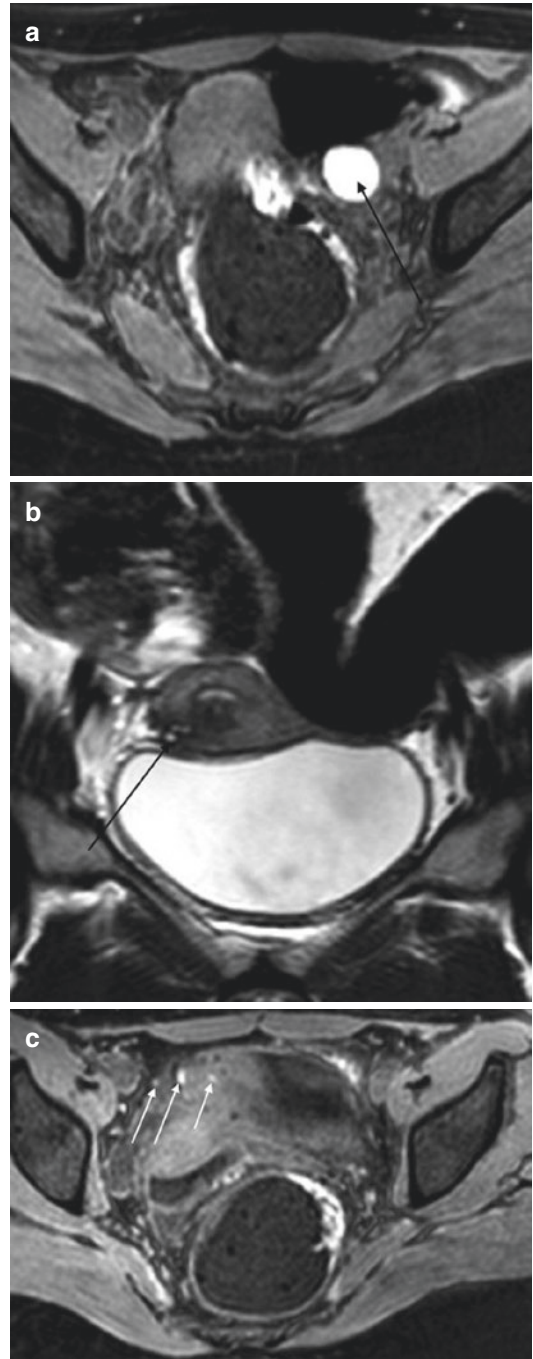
Left endometrioma and bladder endometriosis in a 16 year-old girl. History of cyclical pain after resection of an one-eyed uterine horn. (a) MR imaging: Axial T1-Weighted fat-saturated sequence. Left ovarian cyst in homogeneous and intense hypersignal corresponding to an endometrioma (*arrow*). (b) MR imaging: Coronal T2-Weighted sequence. Thickening of the space between the uterus and bladder associated with hypersignal microcysts (*arrow*). (c) MR imaging: Axial T1-Weighted fat-saturated sequence. The hypersignal microcysts correspond to hemorrhagic foci (*arrows*)
